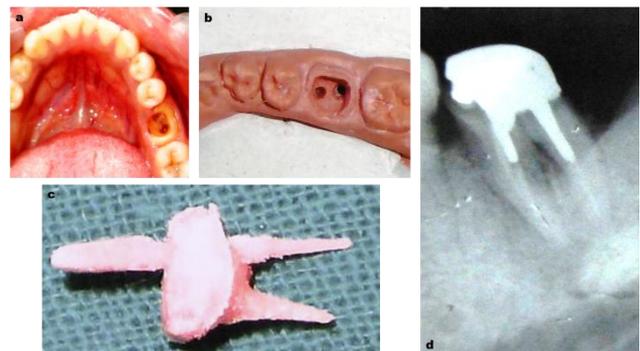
(a) Removal of caries (b) Working cast (c) Pattern resin for cast post core - two unit (d) Radiographic verification of margins
